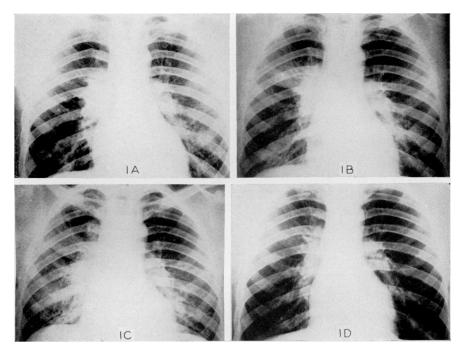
Roentgenograms of Case A. S. 1A on Nov. 10th; 1B on Nov. 14th; 1C on Nov. 18th; 1D on Nov. 26th.
